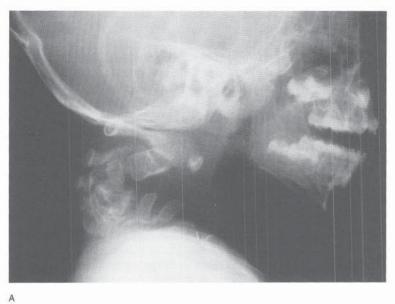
A, Nonunion following attempted posterior fusion and anterior fusion in a 3-year-old child with Larsen's syndrome (same patient as was shown in Fig. 10–18). B, Decompression and strut grafting were performed because of neurologic deterioration. C, Radiographic appearance 1 year postoperatively. Full neurologic recovery ensued.
